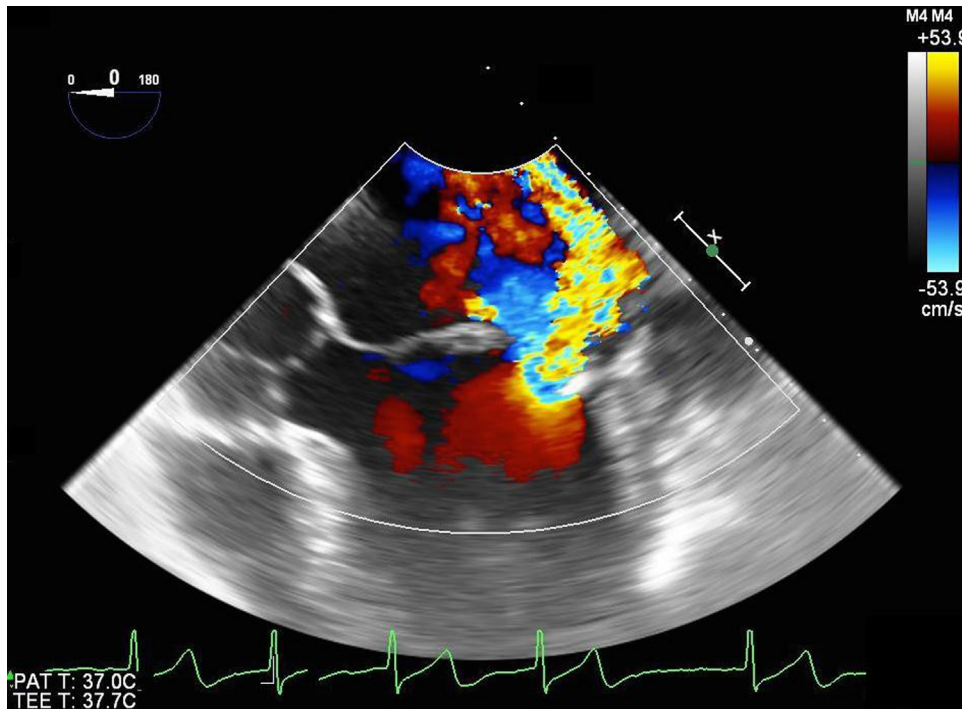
A midesophageal 5-chamber TEE view with color flow Doppler showing mitral valve pathology that resulted in a posteriorly directed regurgitation jet.
